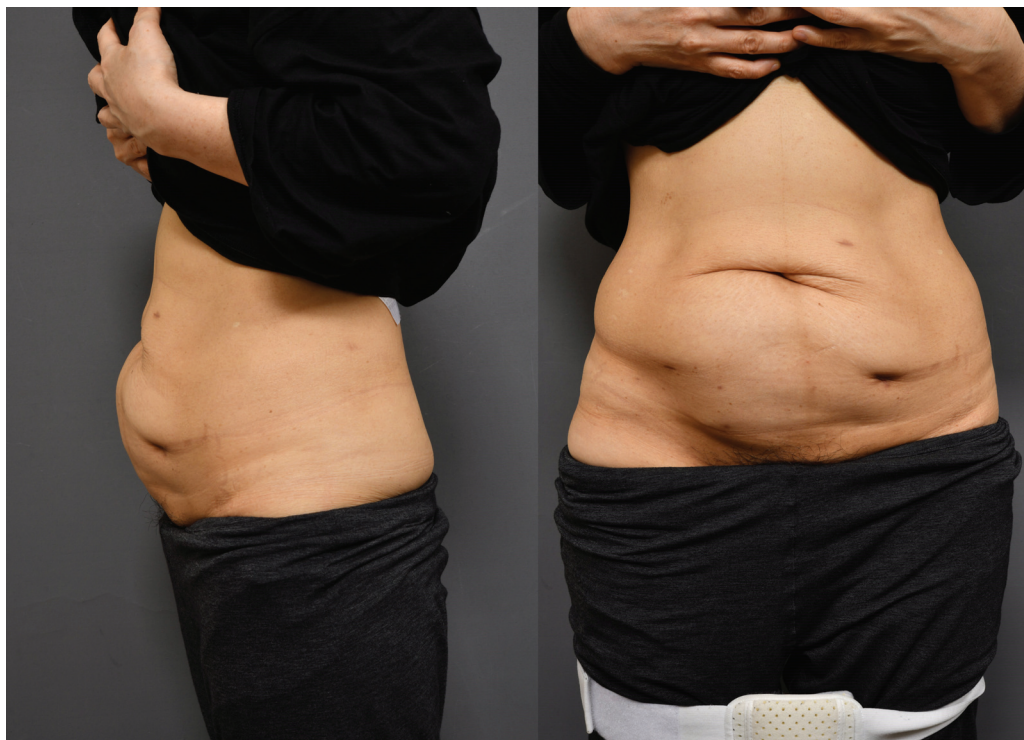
Abdominal wall bulging 12 months after HIFU therapy (lateral view, anteroposterior view). HIFU, high-intensity focused ultrasound.
